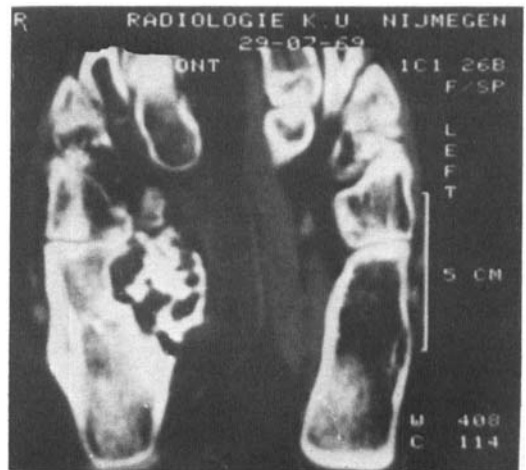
Computed tomography 1983. There is a marked involvement of bone and soft tissues with a multicameral bone lesion.
